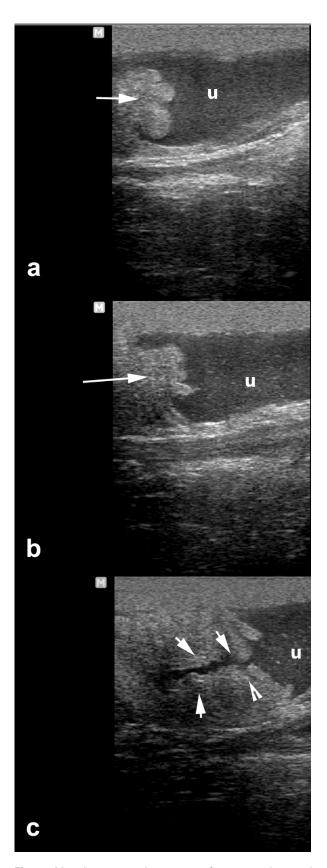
Ultrasonographic image of urine pooling and urometra in a mare. a-b) U= urine in the vagina, arrows indicate the cervix, c) open cervix with urine seeping into the uterus.
